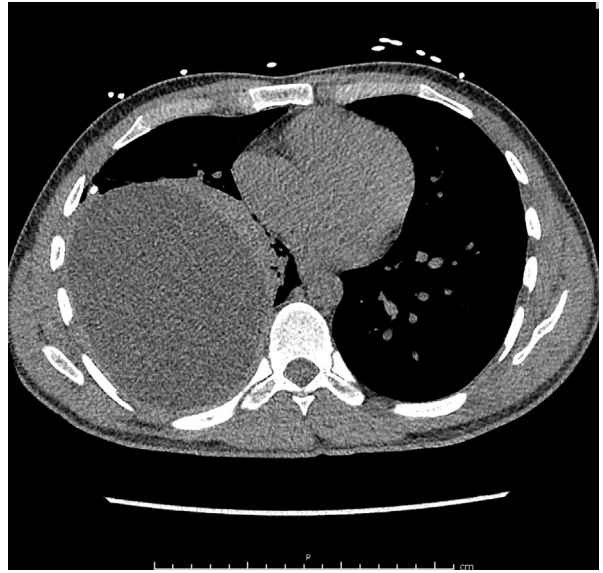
CT scan of the thorax in the axial view, demonstrating a large pleural effusion with atelectasis of the adjacent lung.
